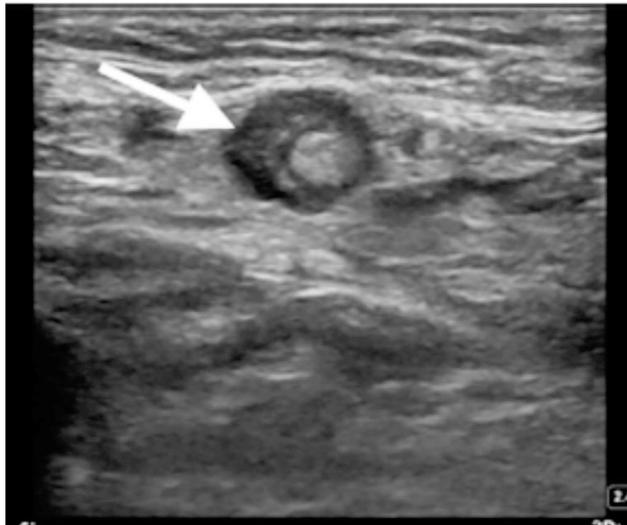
Presence of the vermiform appendix inside the hernial sac that runs under the inguinal canal. Once the ultrasound image was obtained, the repair of the hernia was enhanced with a prosthesis and the removal of the appendix.
